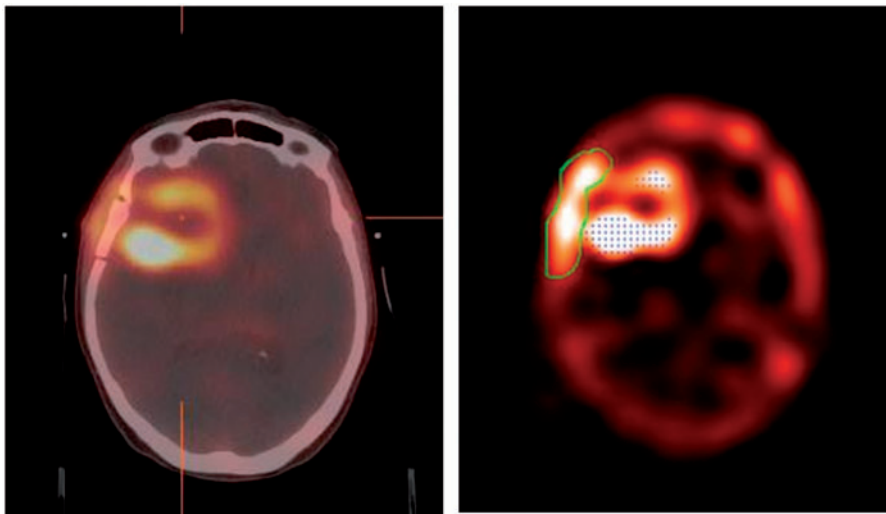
Example of a reconstructed quantitative ^{201}Tl SPECT with a Butterworth filter, co-registered to the radiotherapy treatment planning CT (left), and the corresponding threshold grown ROI (right).
